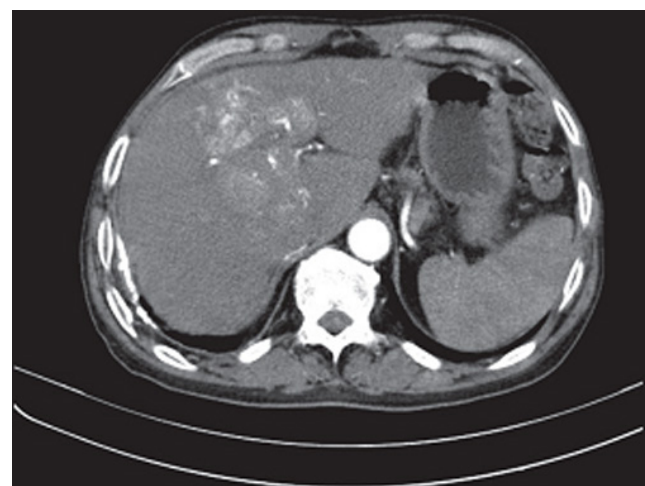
Computed tomography scan of abdomen showing heterogeneous enhancing mass in segment VIII and IV in liver in the arterial phase
